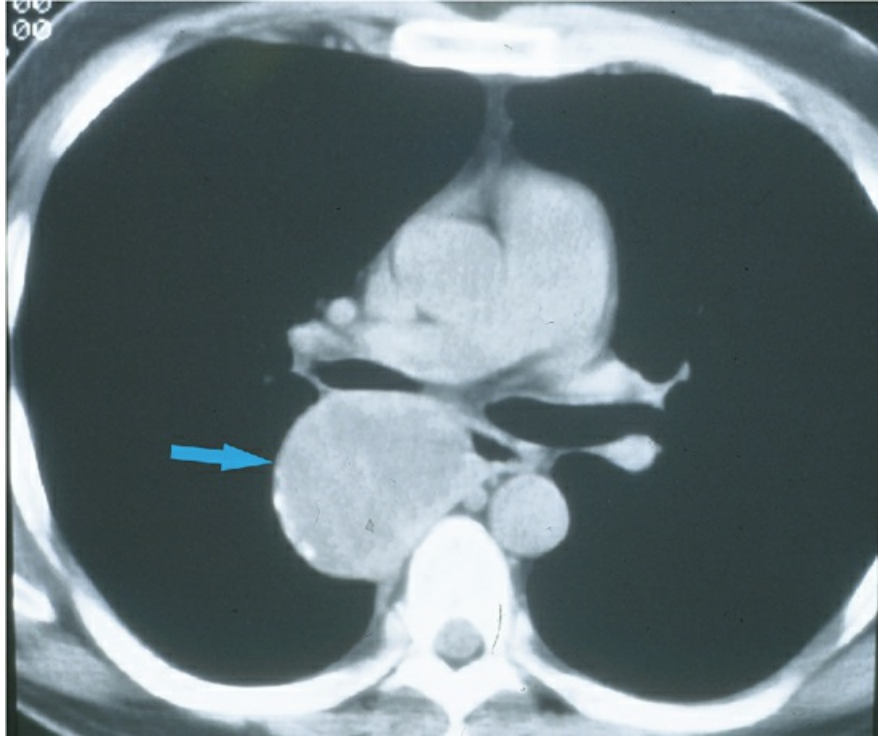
Chest computed tomography scan of a patient with a bronchogenic cyst appearing as a mass in the middle and posterior mediastinum (arrow). *Source:* (Courtesy of Dr. Paul Stark.)
